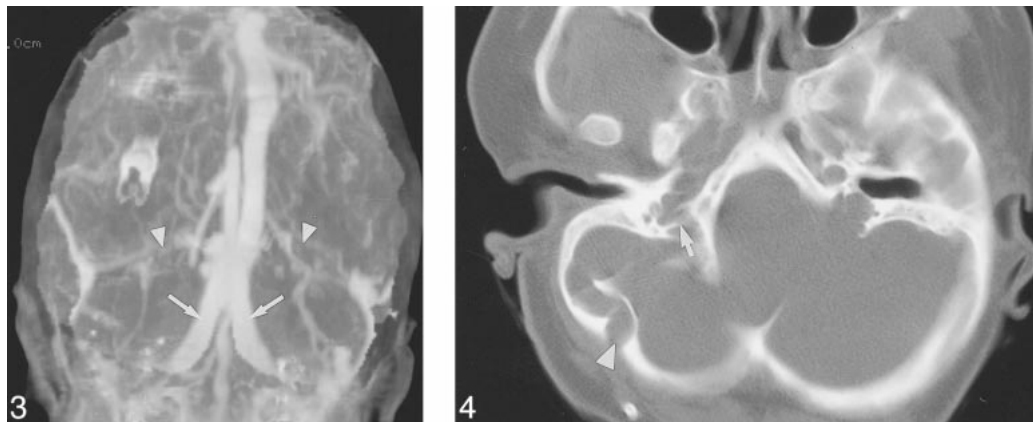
Case 5: Three-year-old girl with Pfeiffer syndrome and FGFR2 cys342arg mutation. Frontal MIP of a CT venogram shows occlusion of the transverse sinuses (*arrowheads*) and large duplicated occipital sinuses (*arrows*).
